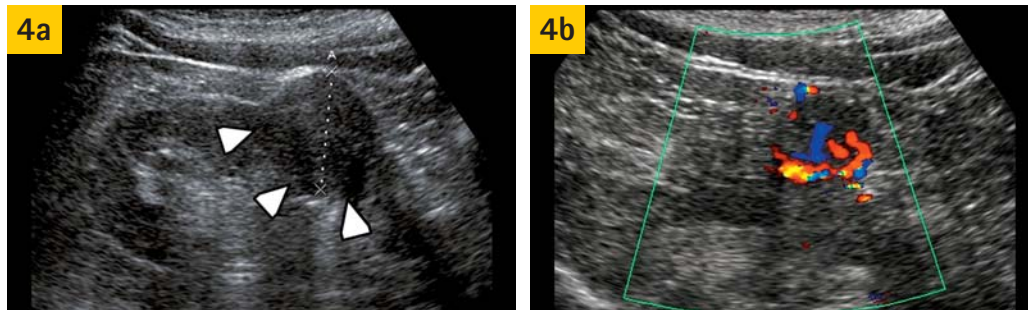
The tumor was isoechoic to the surrounding cortex and mainly identified due to the mass effect (Fig. 4a). Large vessels were detected within and around the tumor at color Doppler US (Fig. 4b).
